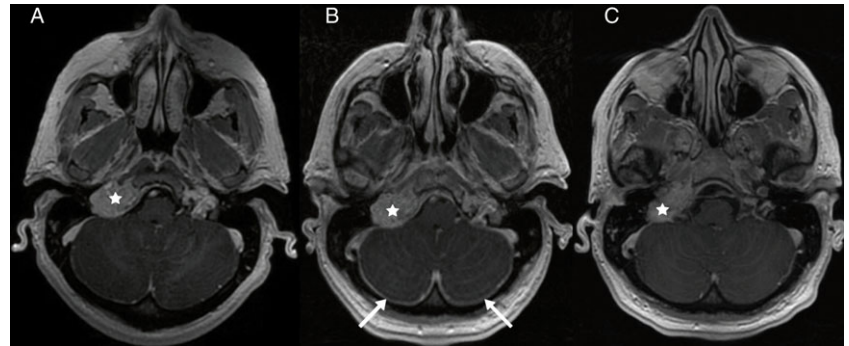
MRI Head (Axial T1 post-gadolinium) before (A) and after (B) radiotherapy, as well as at follow-up (C), demonstrating right jugular paraganglioma abutting dura (starred). Note pachymeningeal enhancement on image B has resolved on image C.
